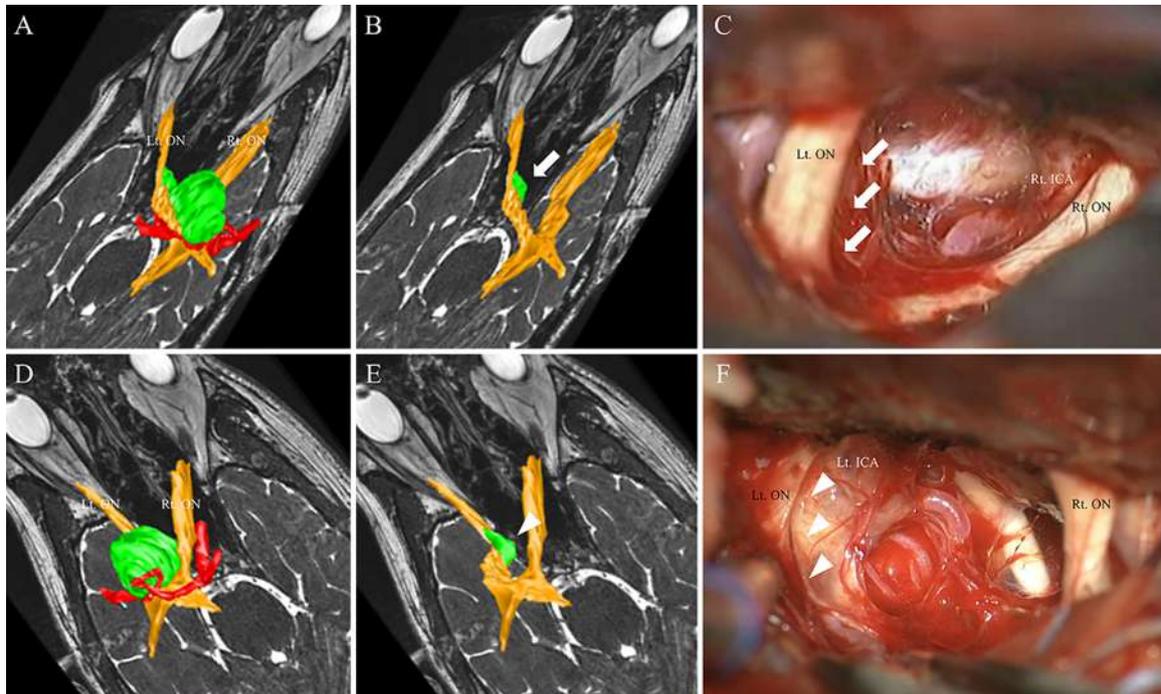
The ipsilateral (A–C) and contralateral (D–F) subfrontal approaches in the 3D reconstruction model based on MRI and the intraoperative view. The 3D reconstruction model (A and B) shows the ipsilateral subfrontal approach. The approach for a tumor (green) located in the inferomedial aspect of the compromised optic nerve (yellow) is blocked by the optic nerve. Red indicates arteries (ICA, ACA, and middle cerebral artery). The intraoperative view (C) demonstrates the blind spot and hidden tumor (white arrows, B and C) in the inferomedial aspect of the optic nerve. The 3D reconstruction model (D and E) shows the contralateral subfrontal approach. The inferomedial aspect of the optic nerve is clearly exposed. The intraoperative view (F) demonstrates the clear view of the inferomedial aspect of the optic nerve. The white arrowheads (E and F) indicate the well-exposed inferomedial aspect of the optic nerve, indented by tumors. Lt. = left; ON = optic nerve; Rt. = right. Figure is available in color online only.
